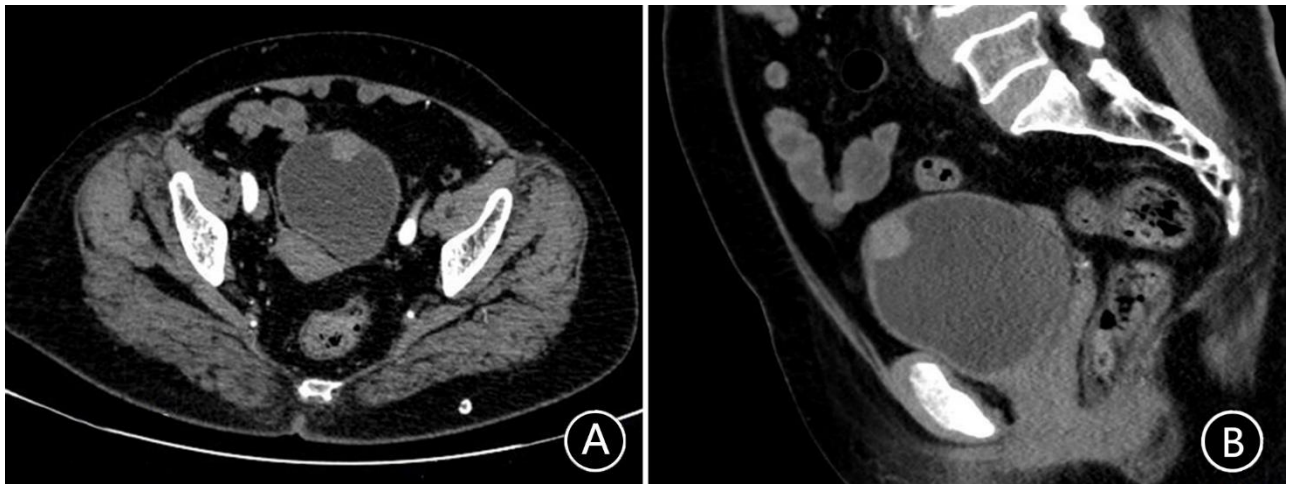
Preoperative pelvic contrast-enhanced CT. Pelvic contrast-enhanced CT showing a localized tumor on the anterior wall of the bladder measuring approximately 1.68 cm×1.72 cm×1.74 cm, which was slightly enhanced. A: transverse plane. B: Sagittal plane.
